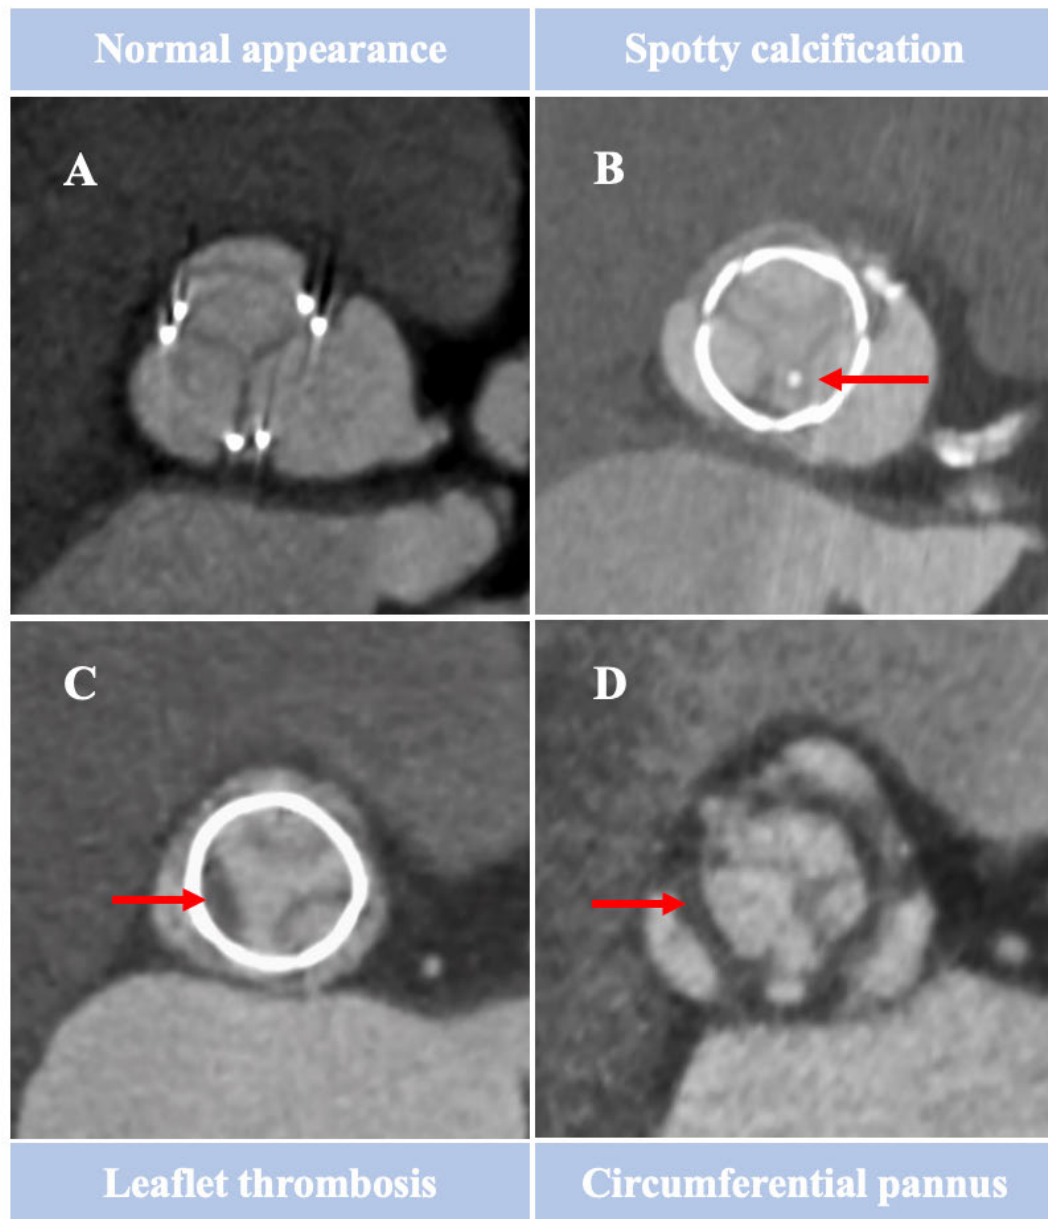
CT can be used to identify bioprosthetic valve leaflet pathology *in vivo*, for example, normal appearance of a bioprosthetic valve (A), an isolated calcific nodule (B), hypoattenuation leaflet thickening implying leaflet thrombosis (C) and a circumferential rim of low attenuation consistent with pannus (D).
